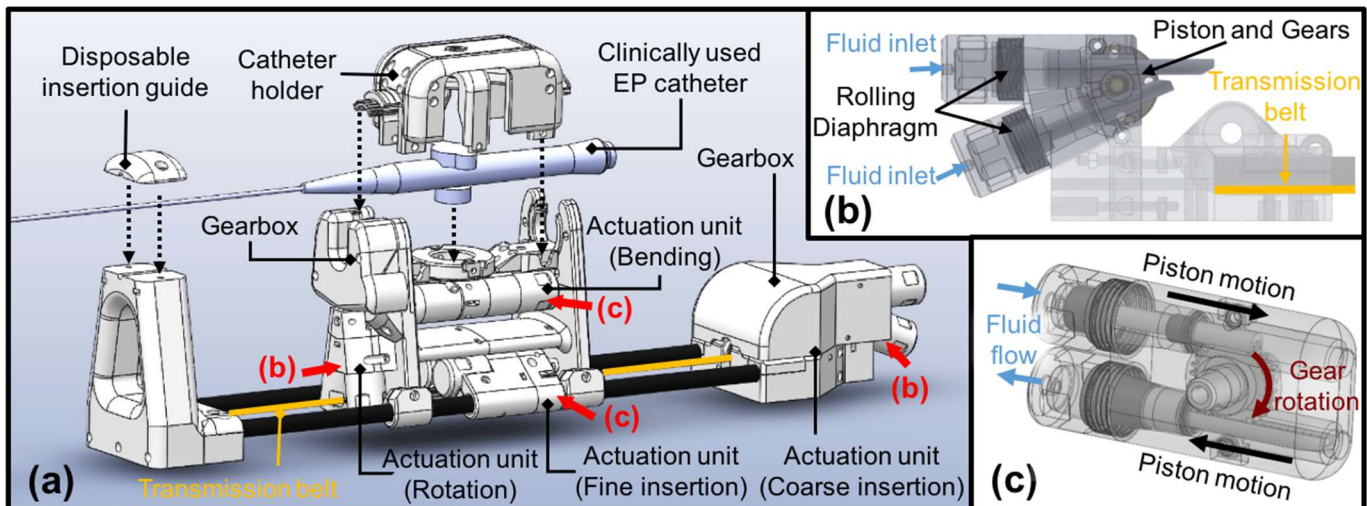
(a) Main components of the MR Safe robotic manipulator (the slave system) which operates in the MRI room. A clinically used EP catheter can be tightly mounted on a tailor-made catheter holder. (b) and (c): The actuation units providing steering, rotation, coarse and fine translation of the catheter.
